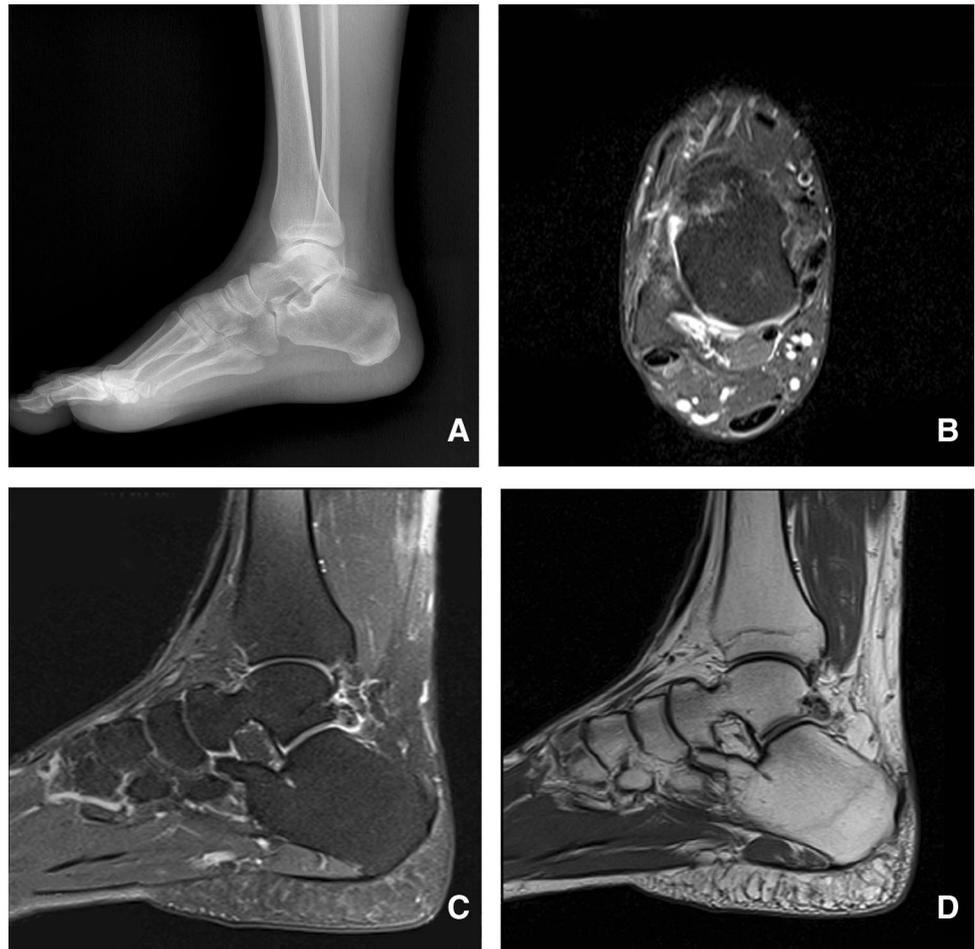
A 35-year-old female presents with persistent posterior ankle pain 6 months following an ankle sprain. a Lateral X-ray of foot showing os trigonum. b Axial PD fat-saturated MR image showing fluid around the flexor hallucis longus tendon with faint hyperintensity within its substance consistent with FHL tenosynovitis. c Sagittal PD fat-saturated MR image showing os trigonum with edema in the posterior aspect of talus and the ossicle. d Sagittal T1W1 MR image showing os trigonum with hypointensity in the posterior aspect of talus and the ossicle. All MR images show soft tissue edema posterior to talus
